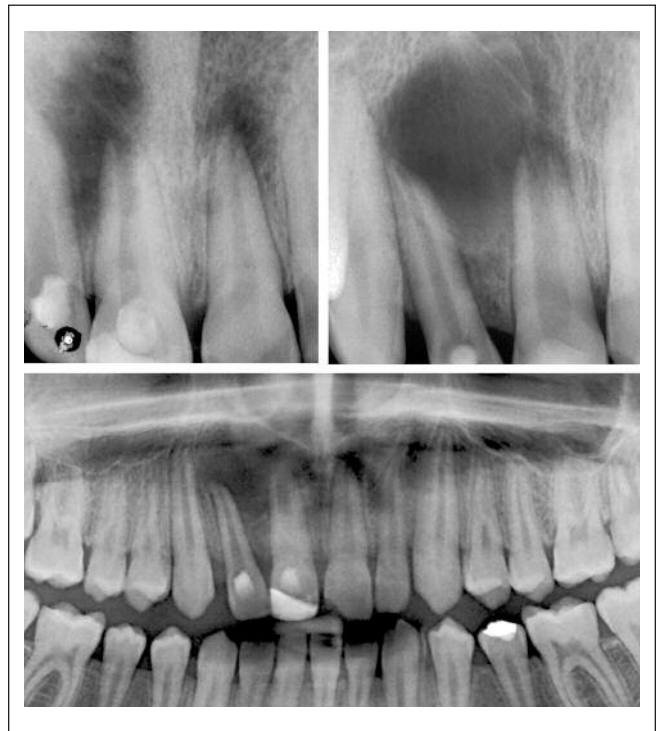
Radiographic view of the incisors, demonstrating the extent of periradicular lesions.
